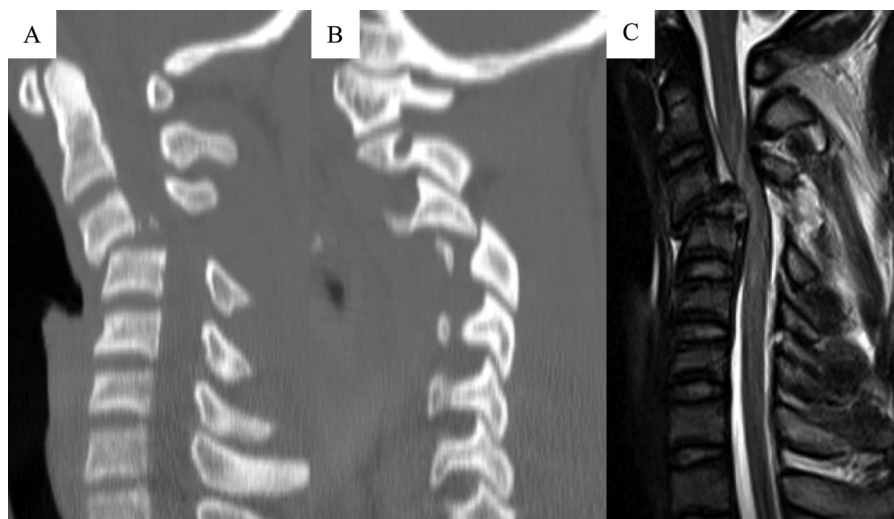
Mid-sagittal (A) and right-lateral (B) reconstruction images of CT and a mid-sagittal view of T2-weighted MR image immediately after injury. The CT images show the cervical vertebral fracture-dislocation at C3/4 (A, B). The MR image shows the compressed spinal cord at C3/4 (C).
